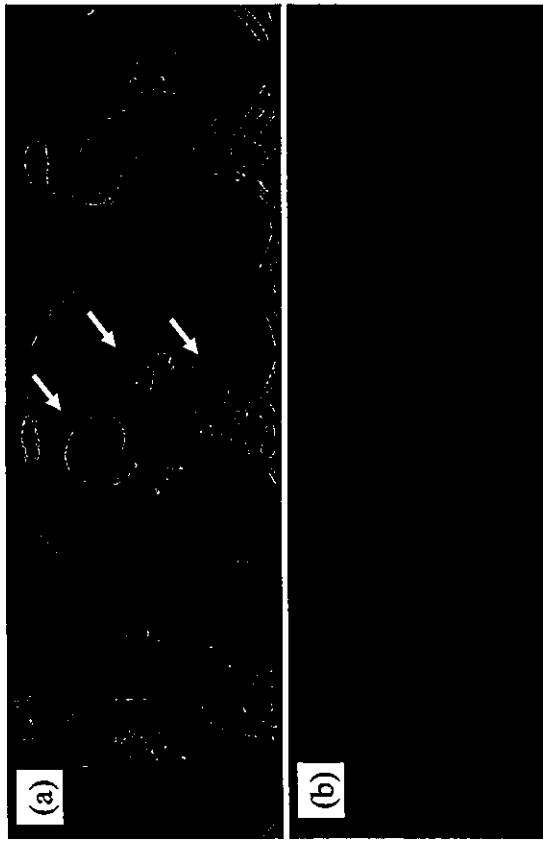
a, Enhanced 2-dimensional computed tomography scan demonstrates 3 circles located in a hook shape beneath aortic arch (arrows), or the "triple star sign." Maximum diameter of the aneurysm is 3.8 cm. Adherosclerotic changes in adjacent aorta were not found. Diameter of descending aorta is 2.6 cm. b, Three-dimensional reconstructions of computed tomography scan show the aneurysm projecting to the left pulmonary artery from the minor curvature of the aortic arch. Aneurysm had thrombus, and compressed the left pulmonary artery.
